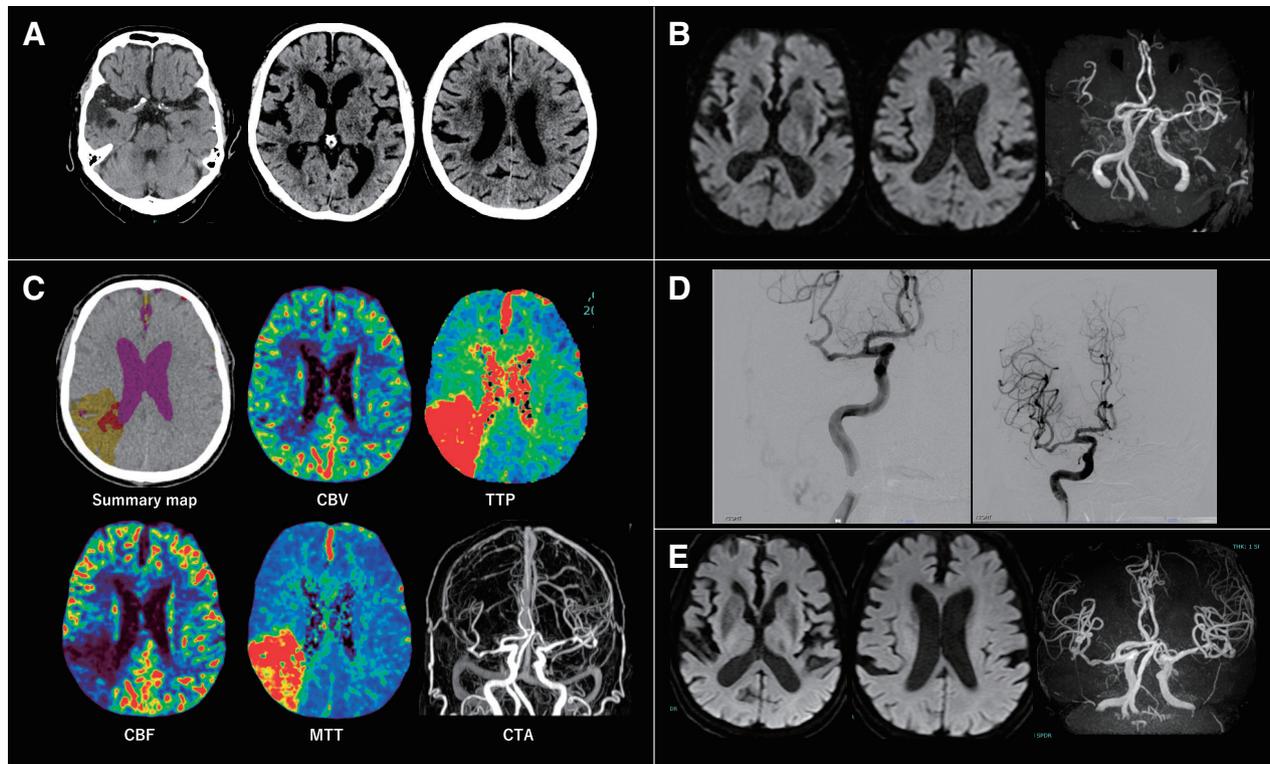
Case presentation: an 80-year-old man with a history of ischemic stroke. He was transferred to our hospital by ambulance because of sudden-onset left-sided weakness. When he came to the hospital, he had left hemispatial neglect, left motor weakness, and sensory disturbance with an NIHSS score of 9. (A) Non-contrast CT 55 minutes after onset shows an old infarction in the right temporal lobe. (B) MRI diffusion-weighted image 75 minutes after onset shows no high signal intensity lesions, and MRA shows the right M1–M2 segment weakly compared to the left one. It is difficult to determine whether the right MCA lesion is residual occlusion due to old infarction or new onset due to recurrent stroke. His symptoms suggest a right parietal lobe lesion. (C) CTP image (Vitrea; Canon Medical System, Tochigi, Japan)
